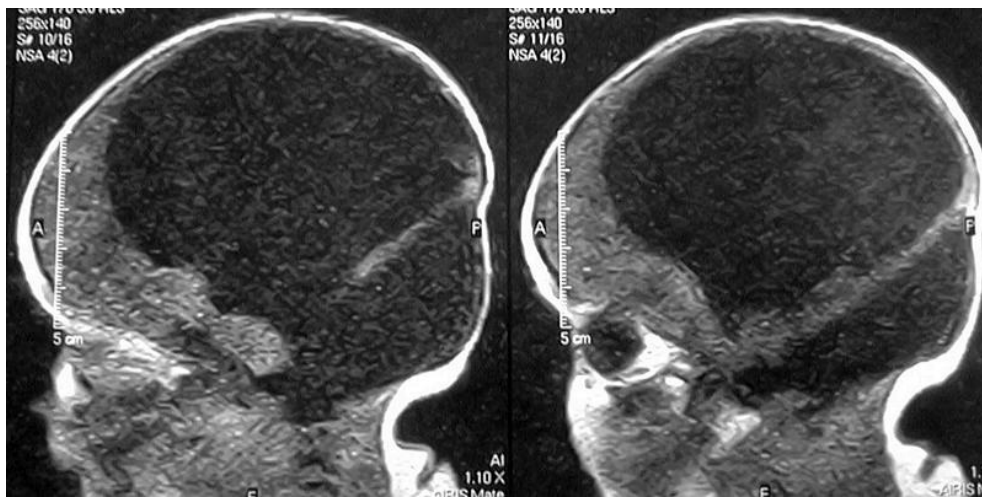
Sagittal cranial MR images show dilated and single ventricular system, deletion of sulci and gyri, fusion in parenchyma and basal ganglia, cerebellar aplasia and absence of corpus callosum, interhemispheric fissure, septum pellucidum and falx cerebri.
